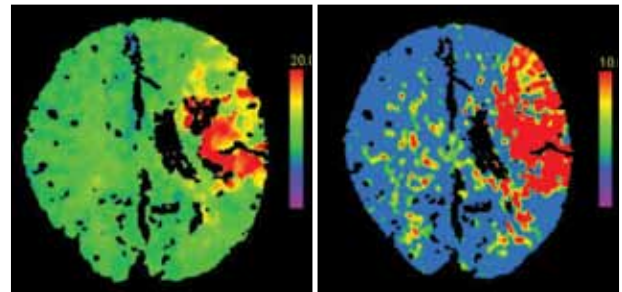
CT axial perfusion images showing the brain at risk using time to peak and mean time to peak.
